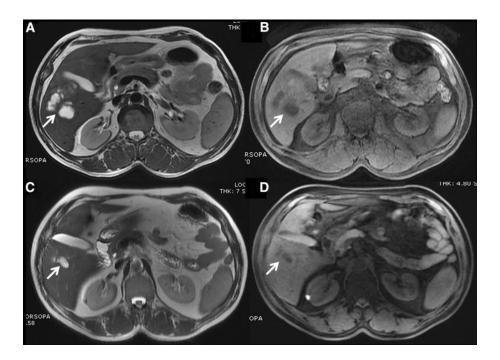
Axial MR scan of 58-year-old male patient, A T2- and B T1-weighted images exhibiting variable signal intensities within the lesions. Follow-up (6 months) MR images (C T2 and D T1) of the same patient showing near total resolution of the lesions.
